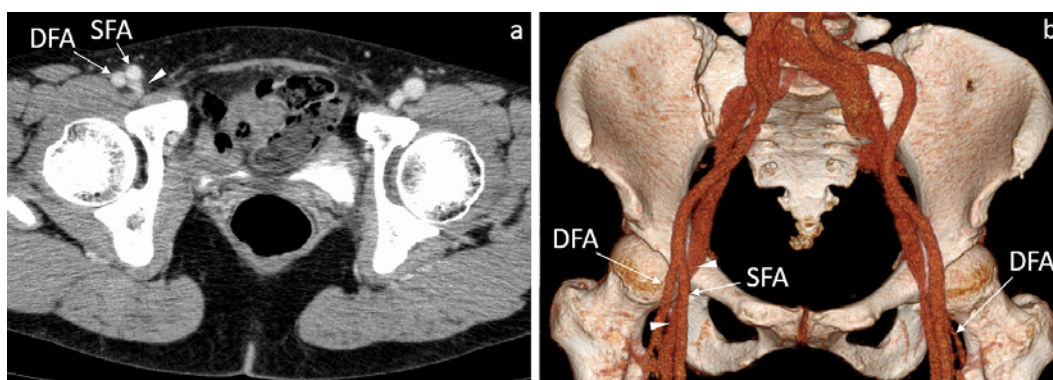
Representative CT images of high deep femoral artery (DFA) bifurcation in type H1 (subtype Ha) in a 60-year-old woman (a, b). The right DFA bifurcates high running laterally to the superficial femoral artery (SFA), which lies on the femoral vein (arrowheads). The left DFA has no variations. The left femoral approach was selected.
